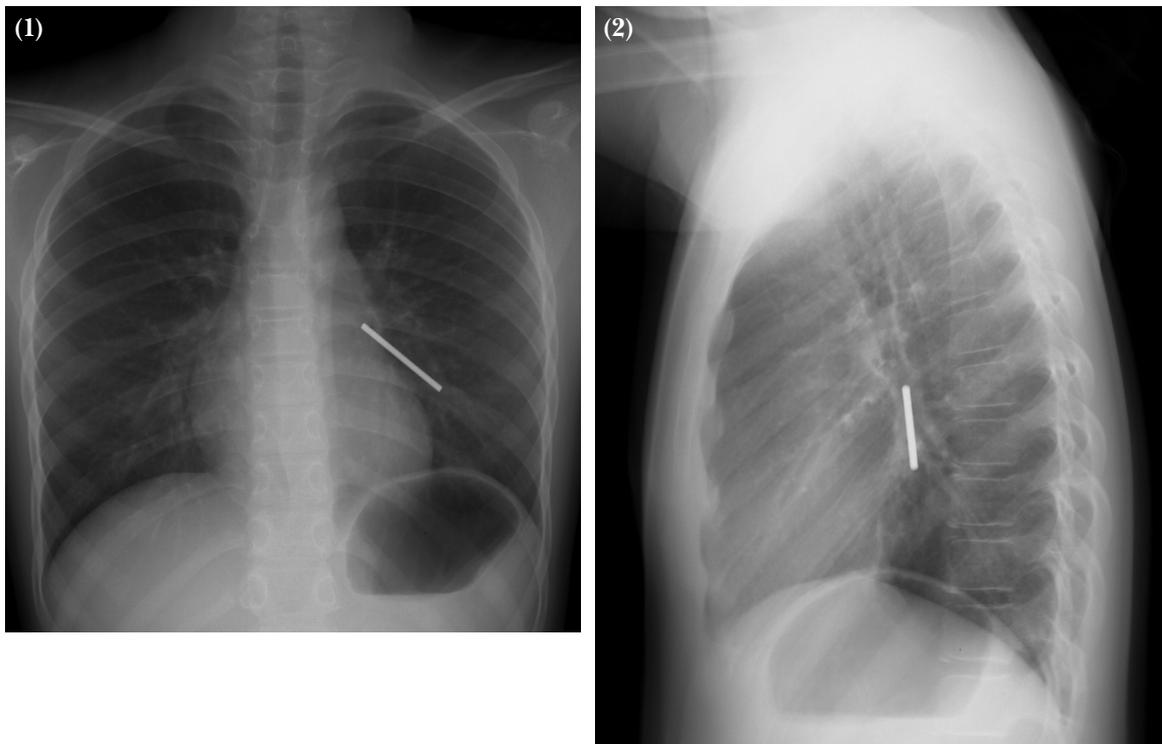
Chest radiography
